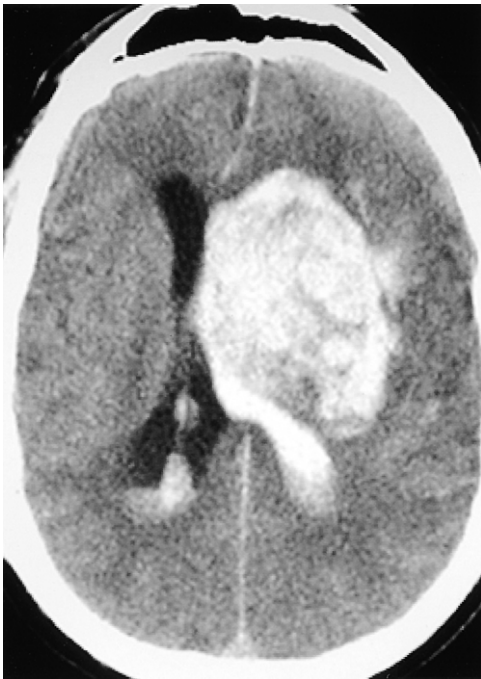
A 57-year-old woman presented with acute stroke. Initial screening CT was normal, and intra-arterial thrombolysis was administered. Approximately 6 hours later, she acutely declined, and a follow-up CT scan revealed a large intraparenchymal hemorrhage with intraventricular extension.
